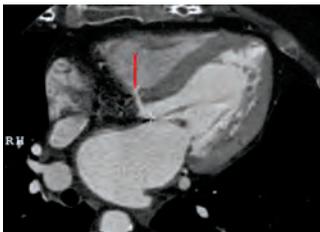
Cardiac CT after TAVI demonstrating ventricular septal defect.
